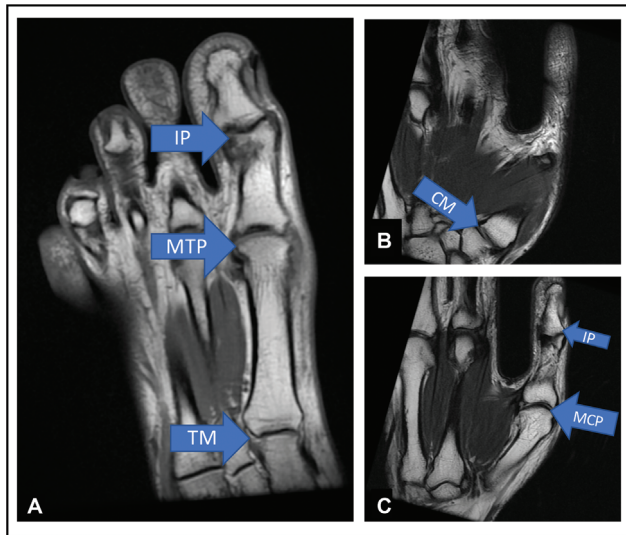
Overview of the joints of great toe and thumb. (A) Axial T1-weighted (T1W) magnetic resonance (MR) image shows that the great toe lies in the same plane as the rest of the toe. The tarsometatarsal (TM) joint, metatarsophalangeal (MTP) joint, and interphalangeal (IP) joint are marked. (B and C). Serial sagittal T1W MR image of the thumb shows that the thumb lies at almost ninety degrees to the plane of the rest of the fingers and is rotated medially. The first carpometacarpal (CM) joint, metacarpophalangeal (MCP) joint, and IP joint are marked.
